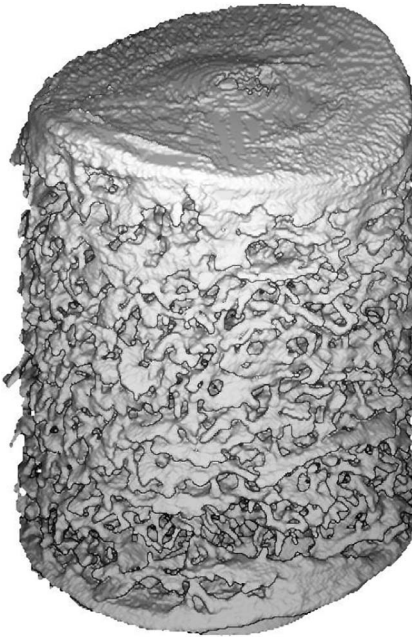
Rendered image of a micro-CT scan of a human calcaneal bone core. Reprinted from *Ultrasound in Medicine and Biology*, vol. 33, Kaufman J. J., Luo G. M., Siffert R. S., "A portable real-time ultrasonic bone densitometer," pp. 1445–1452, Copyright (2007), with permission from Elsevier.
